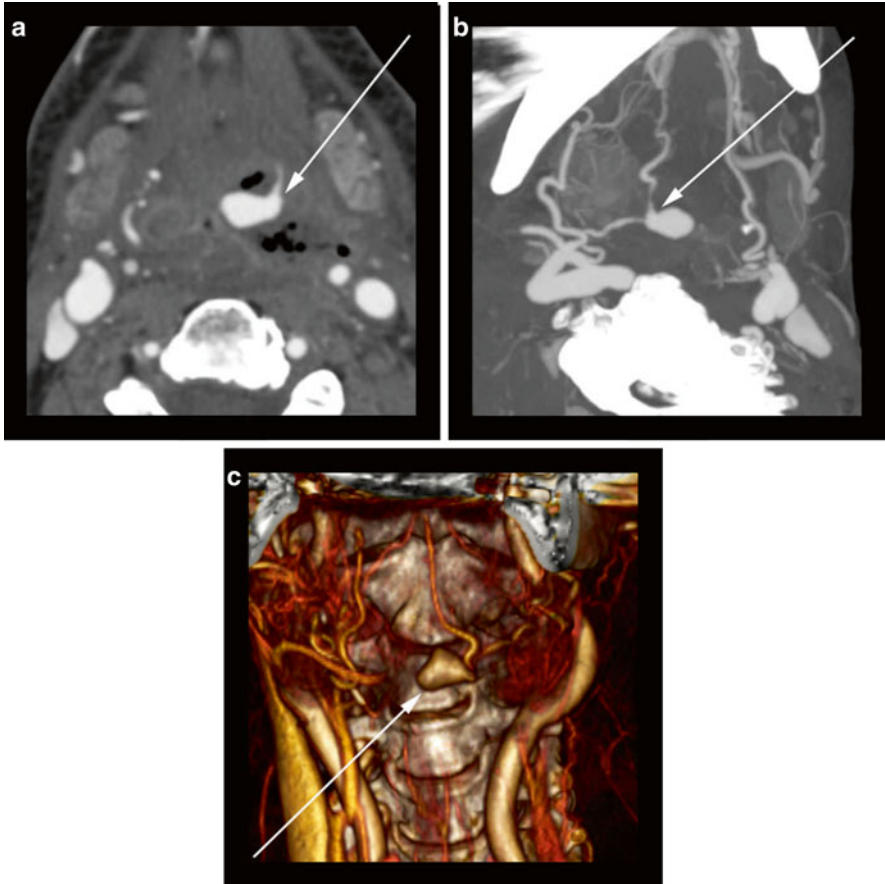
52-year-old woman with head and neck cancer status post-surgical resection, flap reconstruction, and radiation therapy. (a) Axial CTA image reveals a large pseudoaneurysm (*arrow*) involving a branch of the external carotid artery surrounded by necrotic oropharyngeal tissue. (b) Oblique MIP CTA image displays the course of the parent branch artery from the external carotid artery origin (*arrow*). (c) Coronal orientation 3D volume rendering reveals the irregular shape of the aneurysm (*arrow*) along with information on the relationship to surrounding anatomic structures
